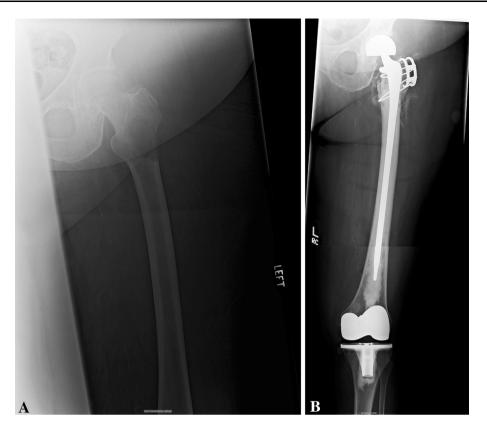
A 72-year-old woman with metastatic breast adenocarcinoma was treated for a pathologic fracture with a long stem hemiarthroplasty. (A) Preoperative radiographs show an impending pathologic fracture of the left proximal femur. (B) Postoperative radiographs show fixation of the impending fracture with a long stem
